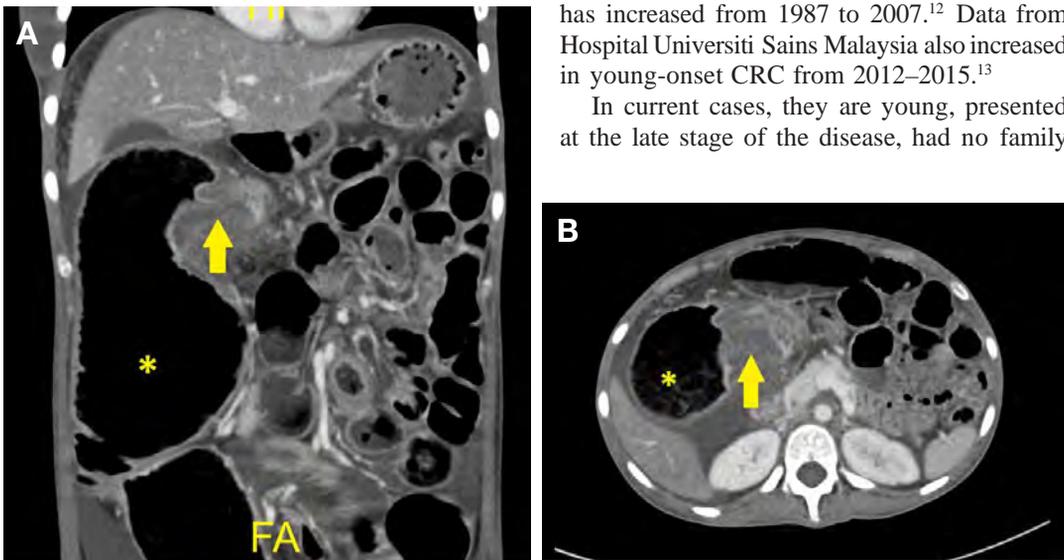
Contrast enhanced CT scan of Case 2. A, a coronal view and B, an axial view showing circumferential bowel thickening at proximal transverse colon (arrow) causing dilatation of the ascending colon (*).
